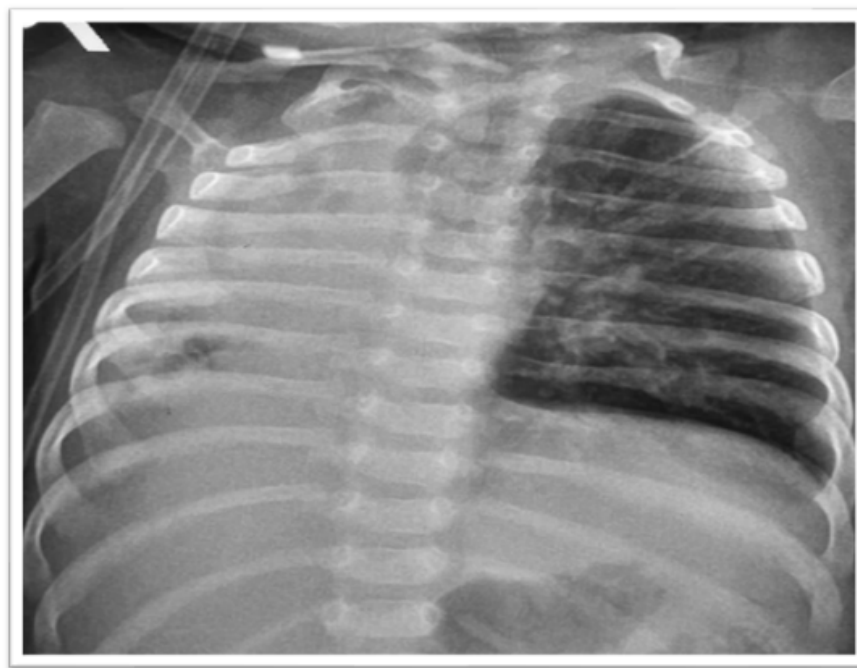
Chest xray AP view showing hazy right lung with ipsilateral mediastinal shift and hyperinflated left lung.
